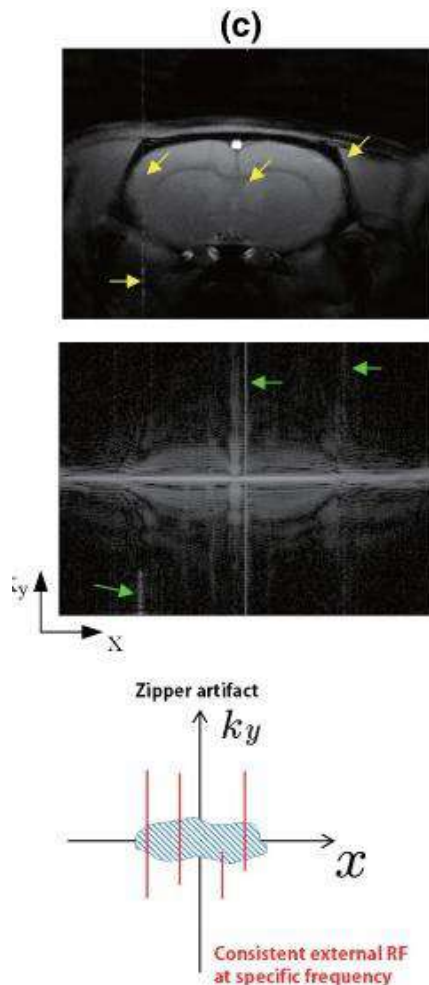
Examples of a motion artifact in an MRI scan. This is one of the patient caused reasons for error in the image reconstruction process. This specific one is called a zipper artifact [5]
